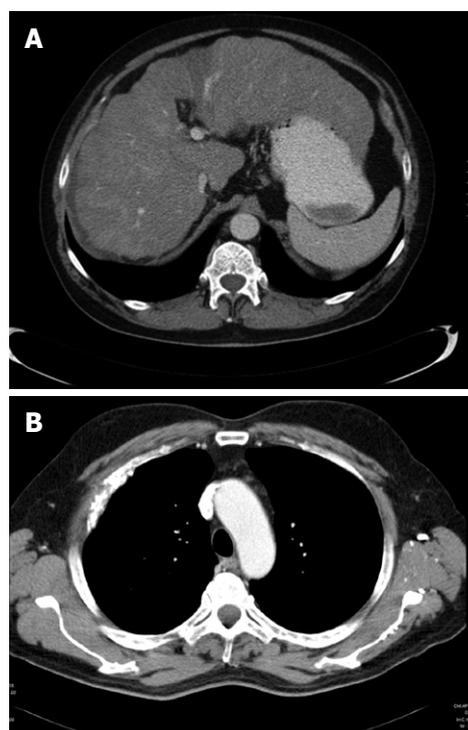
Computed tomography scans of liver (A) and thorax (B) taken in September 2008, 12 mo after initiation of sorafenib therapy showing a dramatic regression of previously described tumor lesions.
